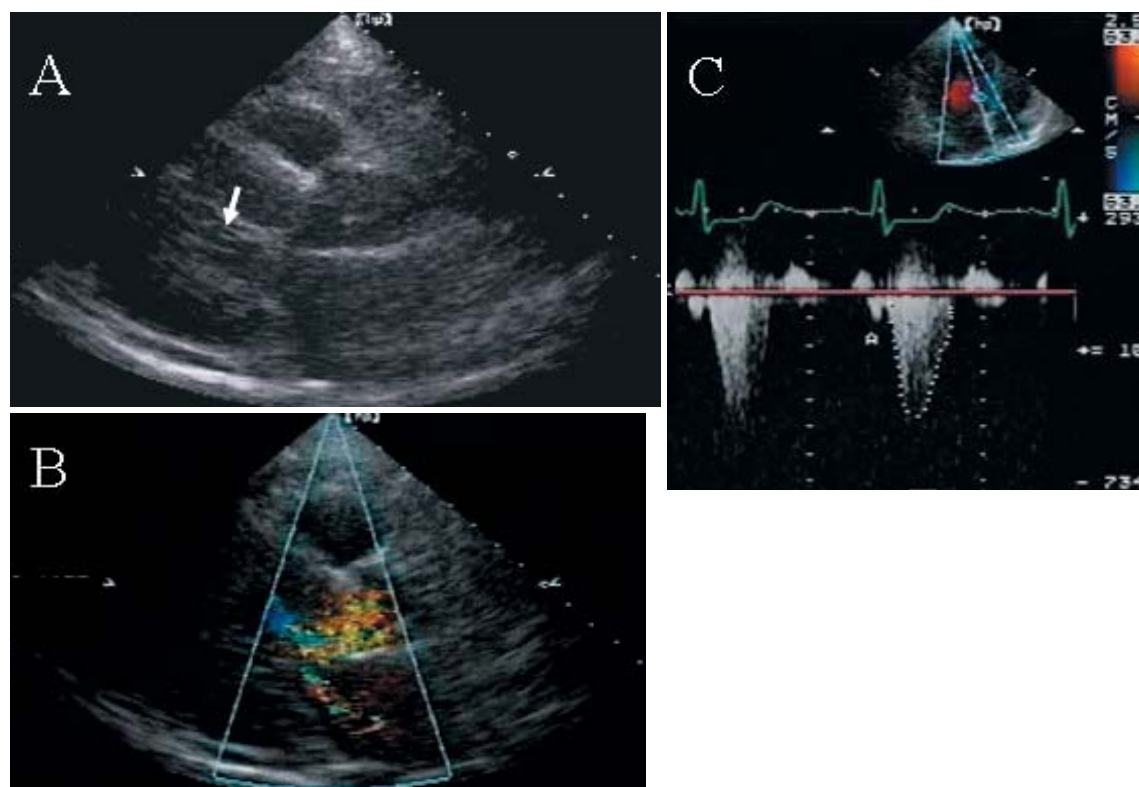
Two-dimensional echocardiograms taken in 1996, showing the apical three chambers
